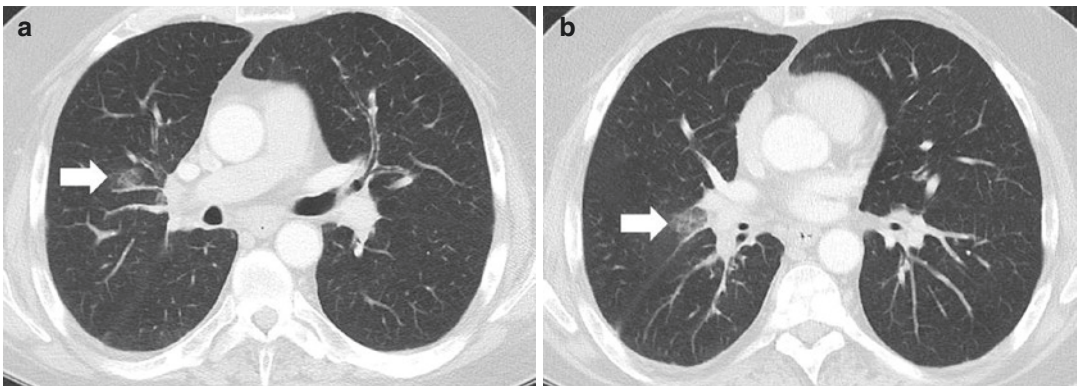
Transient asymptomatic pulmonary opacities (TAPOs) in a 55-year-old man with advanced NSCLC treated with osimertinib. (a, b) CT scan of the chest at 2 months of therapy represented a several foci of new
